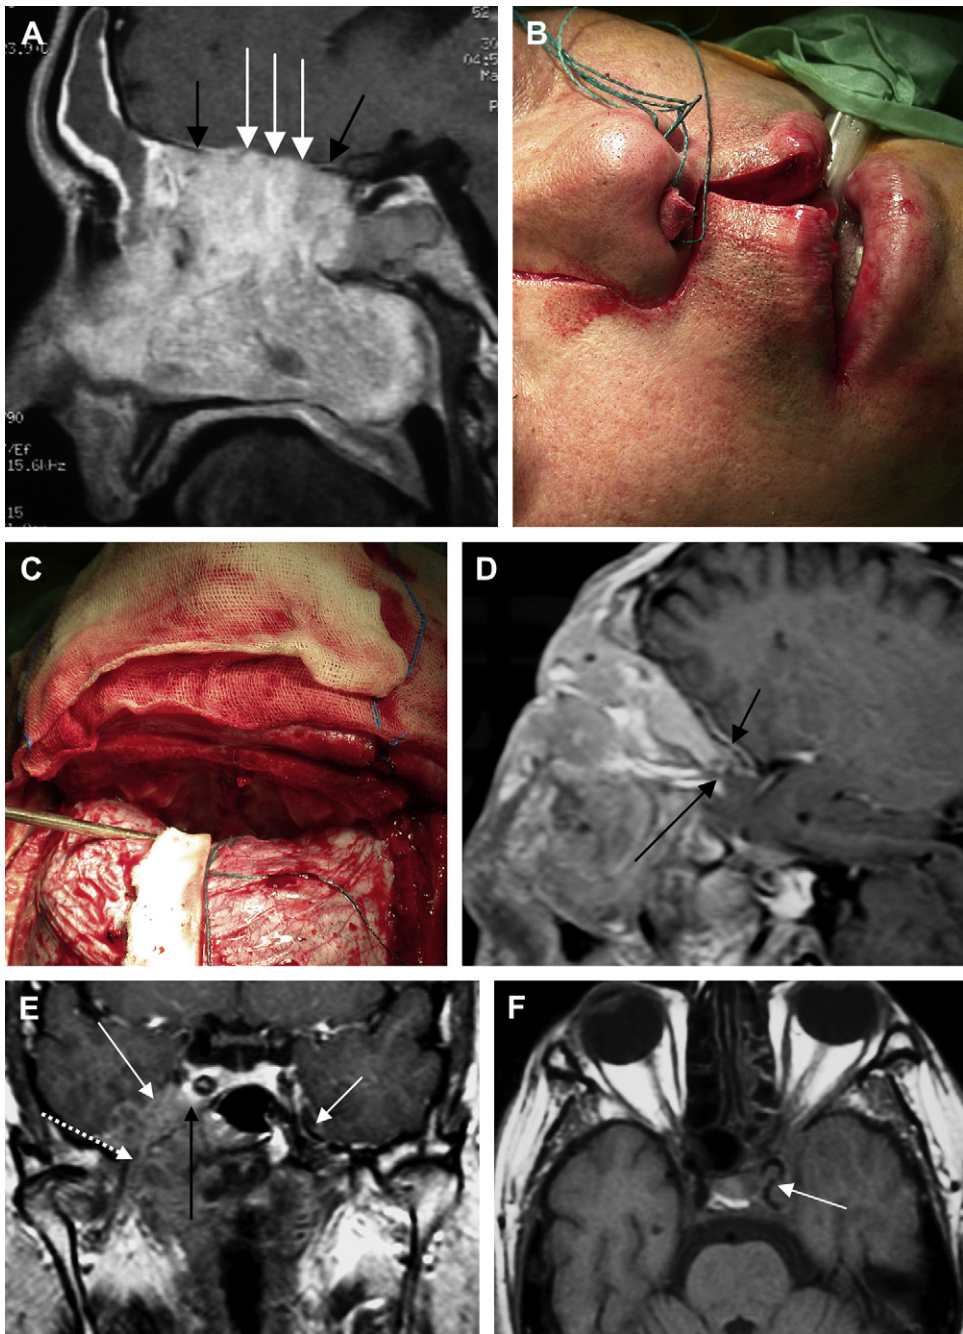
(A) Gadolinium-enhanced sagittal T1-weighted MR imaging shows a large enhancing sinonasal neoplasm transgressing the skull base at the level of the planum sphenoidale. Note the discontinuity of the thin enhancing line corresponding to the dura (*black arrows*) with small areas of tumoral enhancement effacing the adjacent subarachnoid space (*white arrows*), reflecting transdural growth (pathologically proved). No brain edema or enhancement is seen to suggest invasion of the parenchyma. Images of a combined craniofacial resection: parasasal ear, nose, and throat approach (B) and bifrontal neurosurgical approach (C). (D) Gadolinium-enhanced sagittal T1-weighted image shows another sinonasal mass with orbital invasion and posterior extension into the orbital apex (*long black arrow*). Also note the smooth linear dural enhancement along the floor of the anterior cranial fossa (*short black arrow*), suggesting reactive fibrovascular changes. (E) Gadolinium-enhanced coronal T1-weighted image demonstrates a nasopharyngeal mass with infiltrative borders transgressing the CSB. Note the partial obliteration of the left cavernous sinus enhancement (*long black arrow*) and outward bulging of its lateral wall (*long white arrow*). Also, note tumor growth along V3, back to the foramen ovale (*dashed white arrow*), with complete obliteration of Meckel's cave (note the Meckel's cave on the normal side; *short white arrow*). (F) Axial T1-weighted image shows irregularity and stenosis of the right cavernous carotid artery (*white arrow*) attributable to a mass lesion invading the cavernous sinus and orbital apex.
